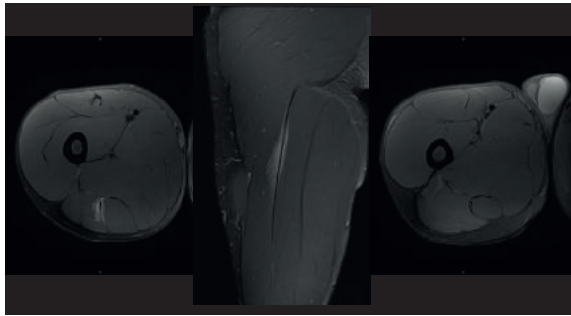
(Case #1). MTJ strain of the central tendon between the long head of the biceps femoris muscle and the semitendinosus muscle. As MRI signs we find paratendinous oedema, tendinous longitudinal disruption and a very slight loss of biceps tendon tension.
